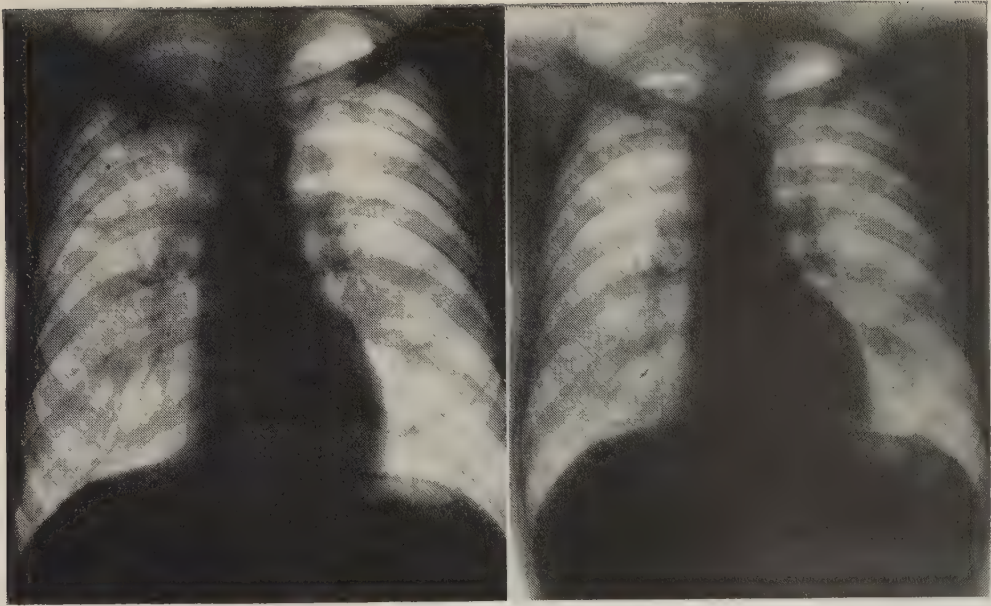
(*Left*) Roentgenograph of chest of patient J. B. shows lesions in the right lung.
